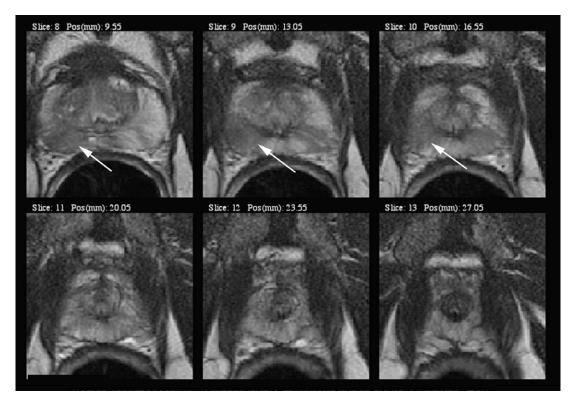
MRI image of the prostate in a patient with a PSA of 3.2 and known Gleason 3 + 3 right-sided adenovarcinoma. Arrows in MRI demonstrate a clear-cut metabolic abnormality in the right midgland extending into the right apex. (Courtesy of Aliya Qayyum, MD, Department of Radiology, University of California—San Francisco.)
